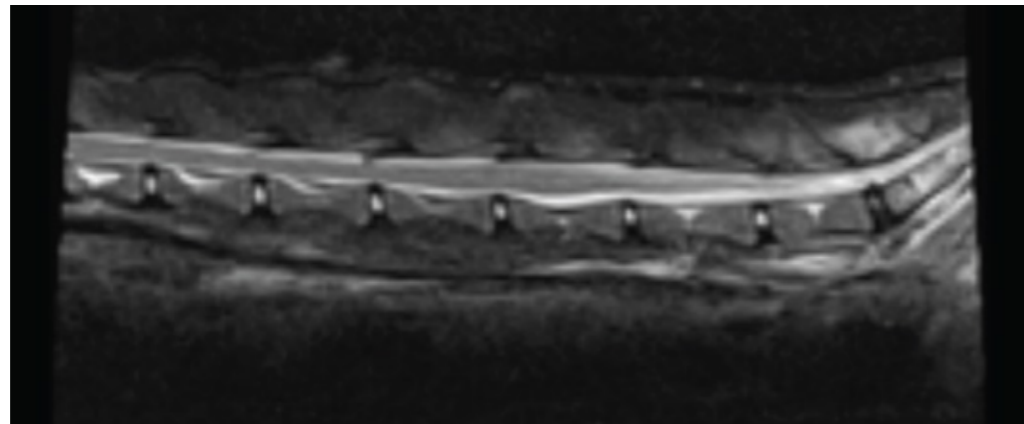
MRI image of lumbo-sacral vertebrae
